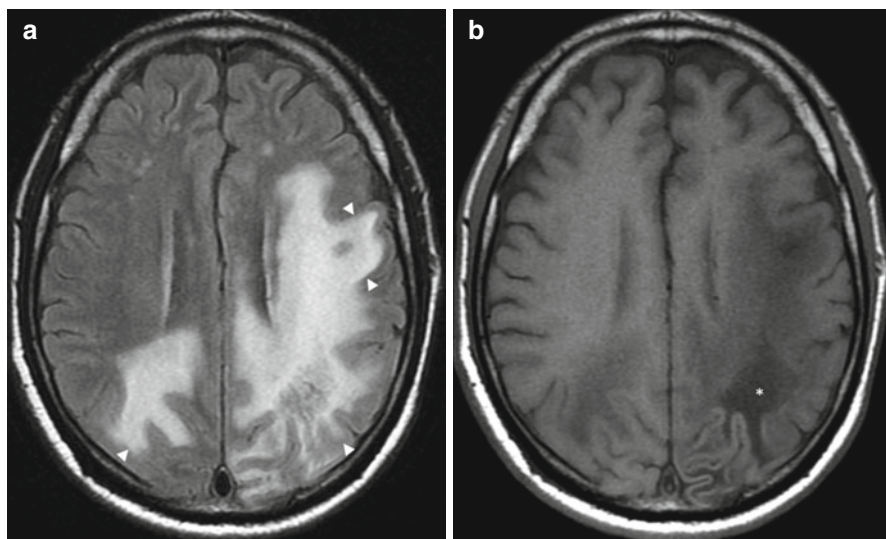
Progressive multifocal leukoencephalopathy (PML) in an immunocompromised patient known to harbour JC Virus. (a) FLAIR image with extensive high signal abnormality in the left cerebral hemisphere involving sub-cortical U-fibers (*arrowheads*). (b) T1-weighted unenhanced image with profound hypointensity (*) often seen in this condition
